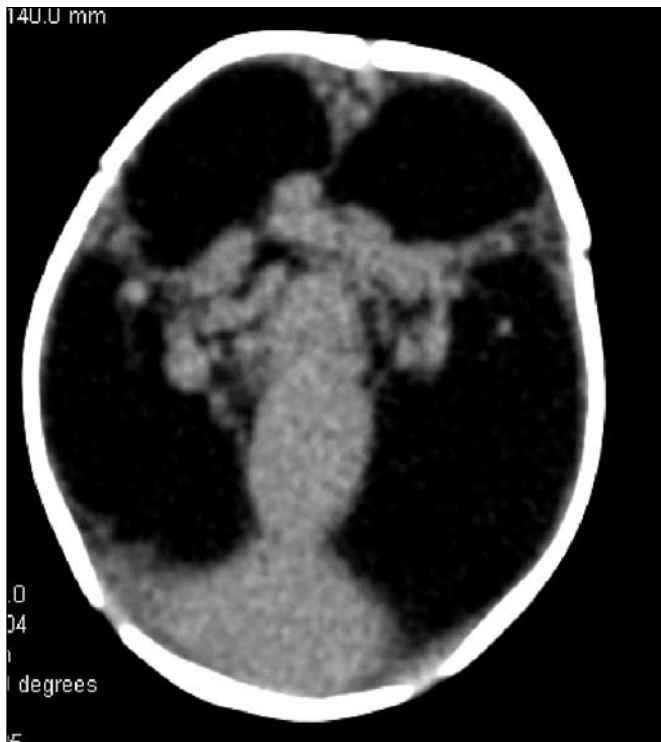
Axial non-enhanced and enhanced computed tomography of the brain demonstrates dilated, tortuous vessels draining into a large vein of Galen with secondary hydrocephalus and astrogliosis with no brain parenchyma.
